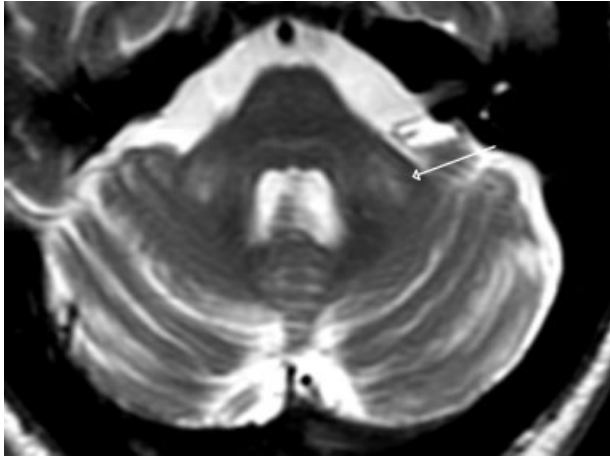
Fifty-nine-year-old male with FXTAS. T2 weighted MR image demonstrates moderate bilateral increase in MCP signal intensity and mild thinning of the oblique transverse diameters of both MCPs. There is mild cerebellar cortical volume loss.
